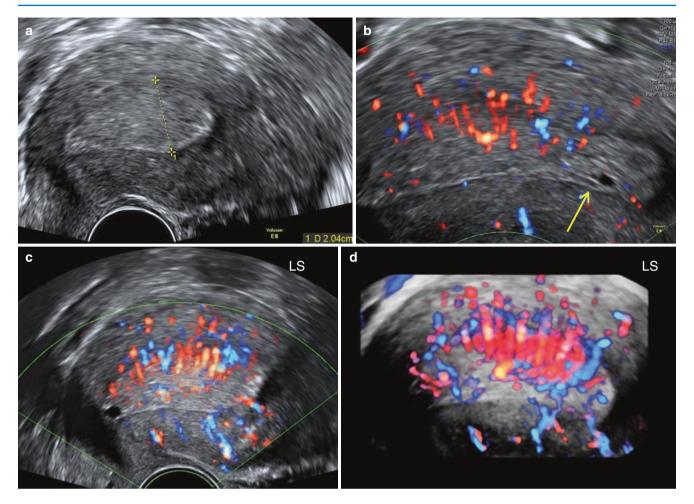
A 31-year-old, known case of endometrioid carcinoma Grade 1 and PCO, on progesterone therapy. (a) 20 mm thick hyperechoic endometrium. (b) Focal area of cystic changes in the endometrium (*arrow*). Multifocal linear single vessels seen crossing the EMJ. (c) On colour Doppler and (d) on 3D Doppler with glass body display
